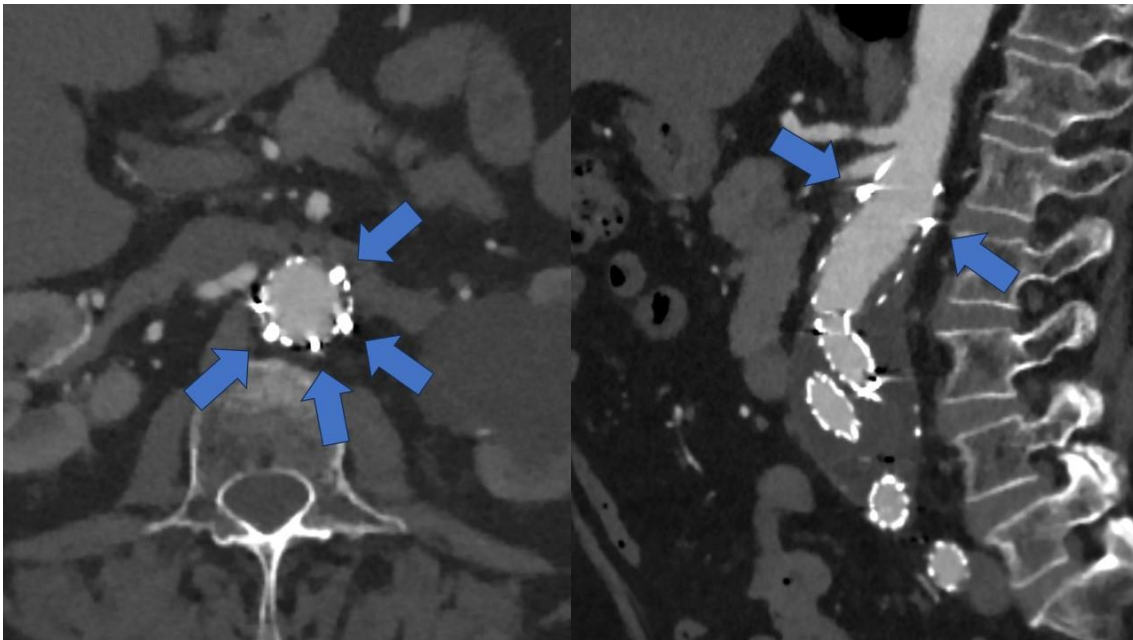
Postoperative follow-up CTA scan after EVAR supplemented with Heli-FX endoanchors. Oblique planar reconstructions show endoanchors (arrows) screwed into the endograft in order to seal the proximal neck used as landing zone. (Image by the author)
